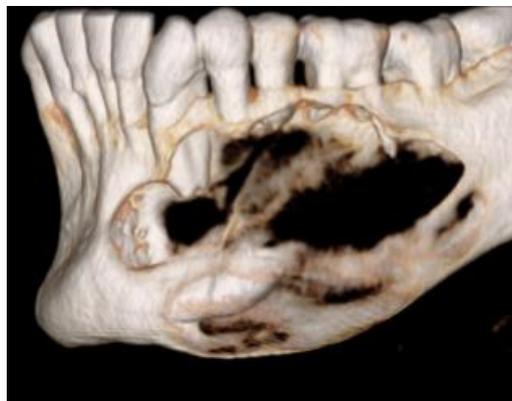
2D & 3D radiograph of ameloblastoma without impacted
